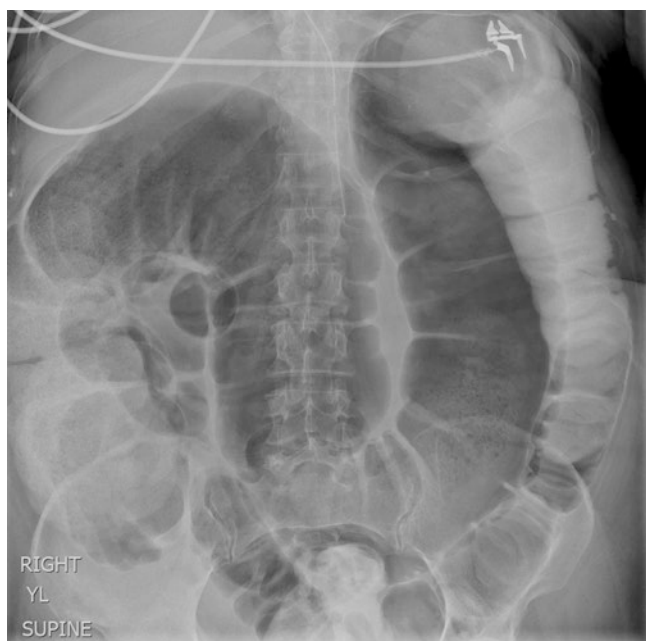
A serial abdominal radiograph of a patient being treated for acute colonic pseudo-obstruction. Notice the dilated right and transverse colon and the relatively decompressed descending colon. Oral contrast has passed through the pseudo-obstructed colon. (Courtesy of Daniel L. Feingold, MD)
